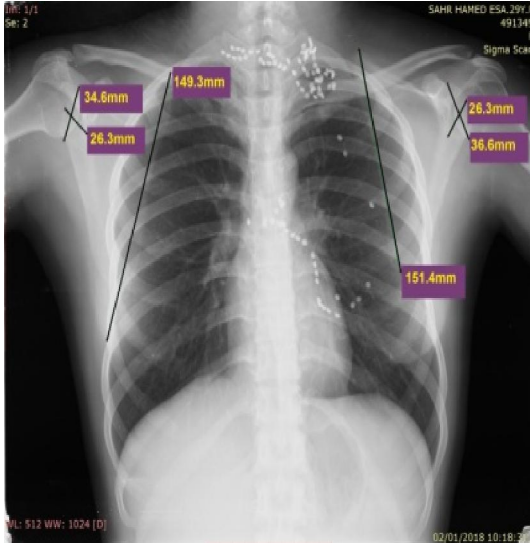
A photograph of plain x-ray of the chest of female aged 29 years showing the parameters of the scapula measured from the anteroposterior roentgenograms of the chest. On left side, Maximum Scapular Length (MSL) is 151.4mm, Glenoid Superior-Inferior diameter is 36.6mm, Glenoid Anterior-Posterior diameter is 26.3mm. on the right side, Maximum Scapular Length (MSL) is 149.3mm, Glenoid Superior-Inferior diameter is 34.6mm, Glenoid Anterior-Posterior diameter is 26.3mm.
